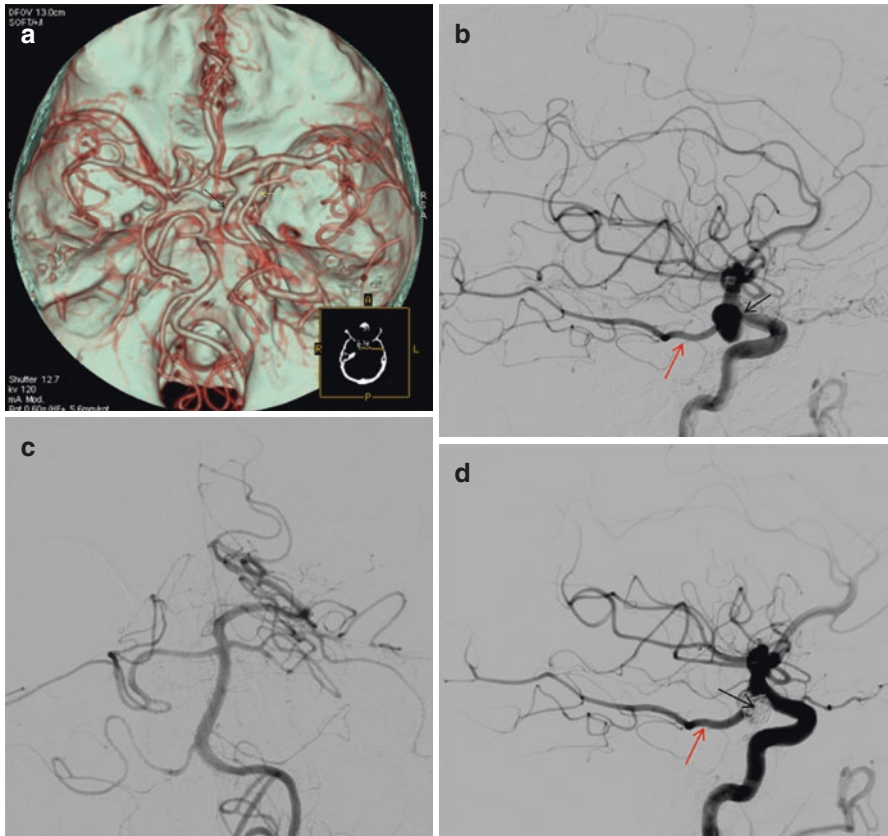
(a) CTA (VRT reconstructions) shows a right sided Fetal Pcom (*black arrow*) with a large aneurysm at the origin of the vessel (*yellow arrow*) (Reproduced from Zampakis et al. [6]). (b) Digital subtraction angiography (lateral view) of the right ICA, shows Fetal Pcom (*red arrow*) and large aneurysm at the origin of the vessel (*black arrow*), which cannot be compromised (Reproduced from Zampakis et al. [6]). (c) Digital subtraction angiography (AP view) of the left vertebral artery. The posterior cerebral artery on the right is not opacified (definition of Fetal Pcom) (Reproduced from Zampakis et al. [6]). (d) Post-embolisation digital subtraction angiography (lateral view) of the right ICA, shows good patency of Fetal Pcom (*red arrow*) and complete obliteration of the aneurysmal sac (*black arrow*) (Reproduced from Zampakis et al. [6])
